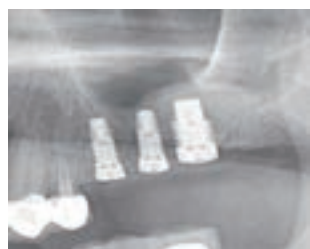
Case 4 radiographic image following additional implant placement.
